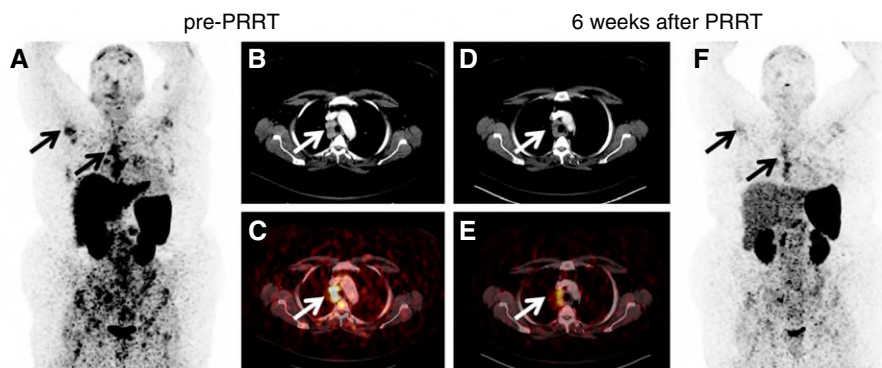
Display of somatostatin receptor–directed positron emission tomography (PET) with ^{68}Ga -DOTA(0)-D-Phe(1)-Tyr(3)-octreotide before and 6 weeks after peptide receptor radionuclide therapy (PRRT) with ^{177}Lu . Display of maximum intensity projections (A and F) and transaxial slices of computed tomography (CT) (B and D) and fused PET/CT (C and E) images before (A–C) and 6 weeks after (D–F) somatostatin receptor–directed PRRT. PRRT resulted in symptomatic relief, as well as a partial morphologic and metabolic response. Both PET projections are displayed with the same intensity. Black arrows in A and F depict osseous lesions in the sternum as well as right humerus. White arrows in B–E show mediastinal lymph nodes.
